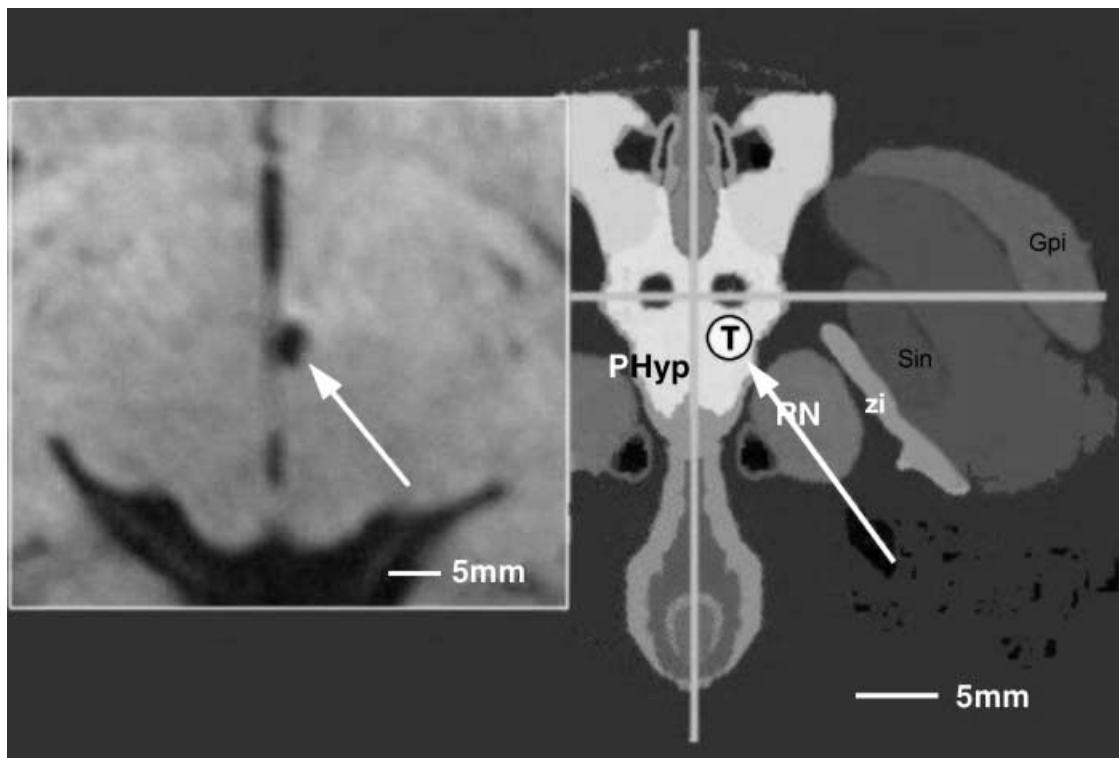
The target for treatment of cluster headache by deep brain neurostimulation. Left: postoperative MRI axial slice of Case 3 with the electrode at the proper target pointed by the arrow. Right: Stereotactic atlas registered to the intercommissural line. The represented axial slice is 5 mm below the commissural plane. The center of the cross is the projection of the intercommissural line midpoint. The arrow points the target area (T) within the posterior hypothalamus as reconstructed and modified from the Van Buren and Borke stereotactic atlas (20).
